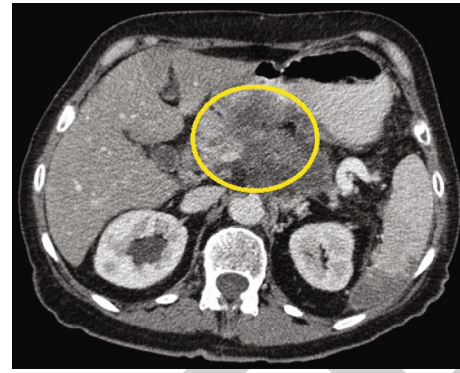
CT scan image of pancreatic cancer tissue.
